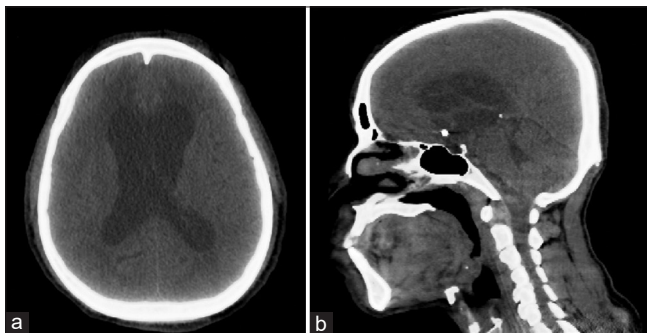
Diagnostic computed tomography (CT) study demonstrating the vestibular schwannoma (a) axial CT and (b) sagittal CT.
